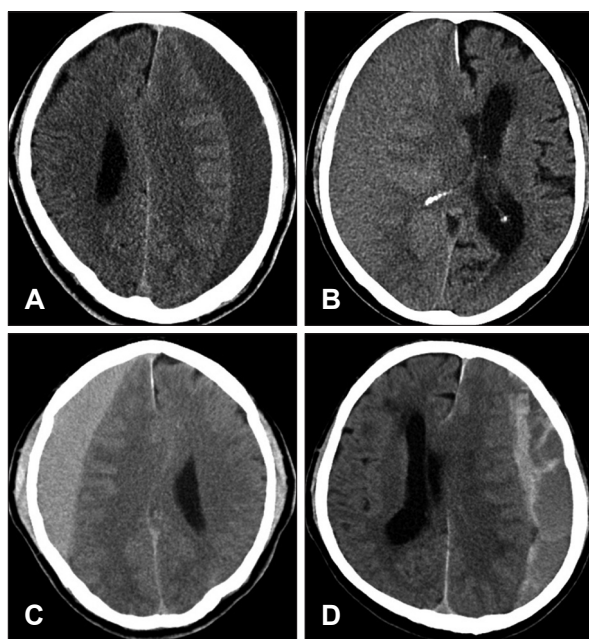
Brain CT showing classification of hematoma density. A: Low-density (4–14 HU). B: Iso-density (14–24 HU). C: High-density (≥24 HU). D: Mixed-density. HU: Hounsfield unit.
